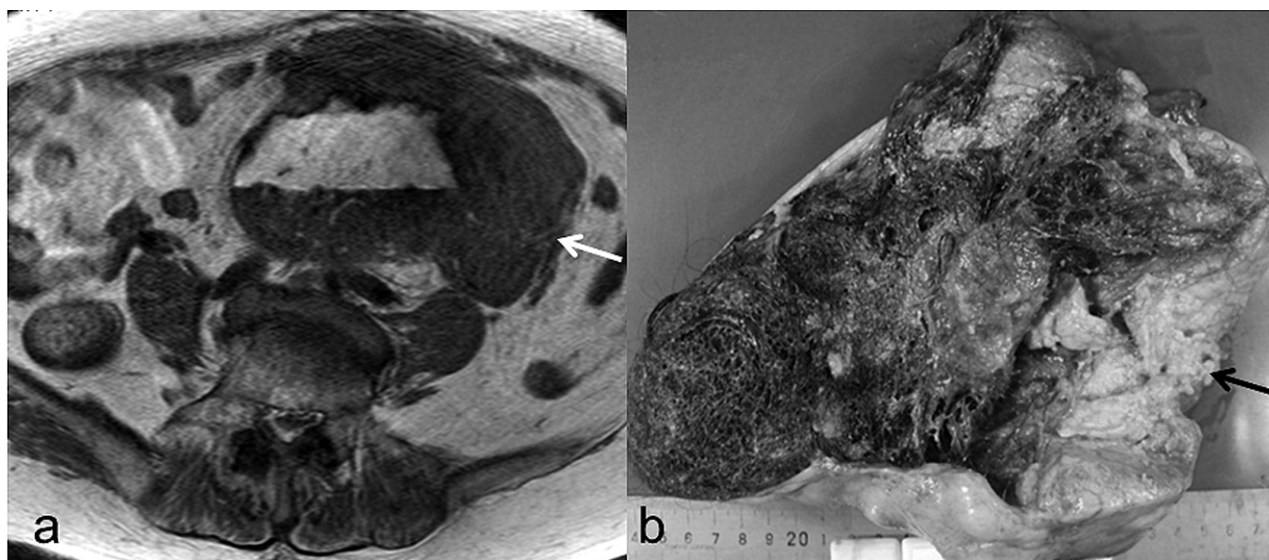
Magnetic resonance (MR) images of the patient and macroscopic view of ovarian tumor. (a) T1-weighted image of ovarian tumor. The tumor had a solid part (arrow) and fatty tissue is shown by high intensity signal. (b) Solid part (arrow) shows a yellow and white appearance, and a cystic lesion containing hair balls, sebaceous materials, bone, and fatty tissue.
